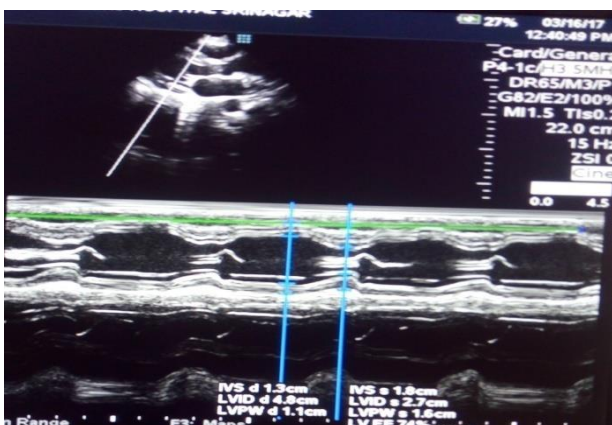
Echocardiography showing normal chamber size and ejection fraction.
